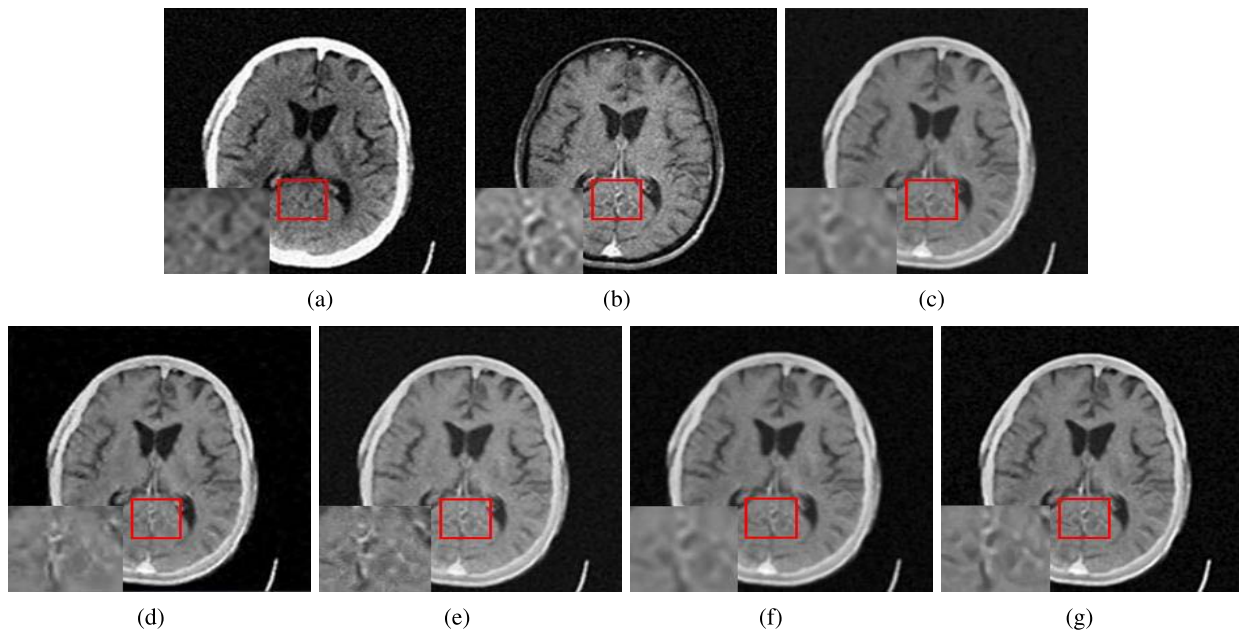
Input images that are added a 13.48-dB SNR and fusion result comparison with different methods. (a) Noisy CT image. (b) Noisy MR image. (c) SR. (d) NGWT. (e) TVPL. (f) BM3D + GFF. (g) Proposed method.
